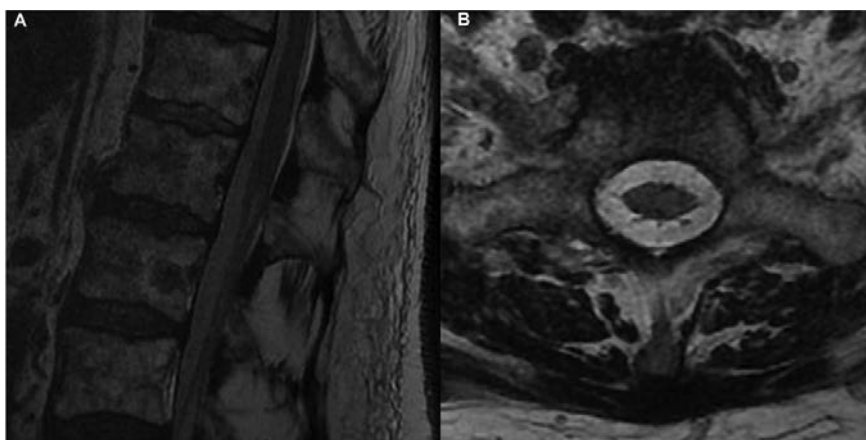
Magnetic resonance images acquired 4 days after the onset of paraplegia. T2-weighted sagittal (A) and axial (B) images show hyperintensity at the T12-L1 level in the form of an anteromedial spot. No other spinal cord lesions were detected.
